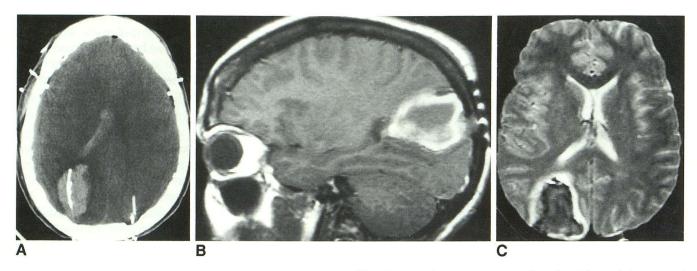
Significant hemorrhage complicating probe placement. CT with acute hematoma surrounding the right occipitotemporal probe posteriorly (A); sagittal (600/11/1) (B), and axial (2000/80/1) (C) images obtained 1 week after hemorrhage and probe removal demonstrate evolving occipital hematoma.
